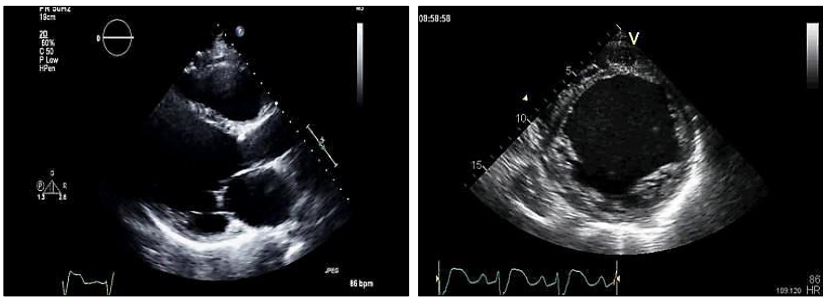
Cardiomyopathyechocardiogram
